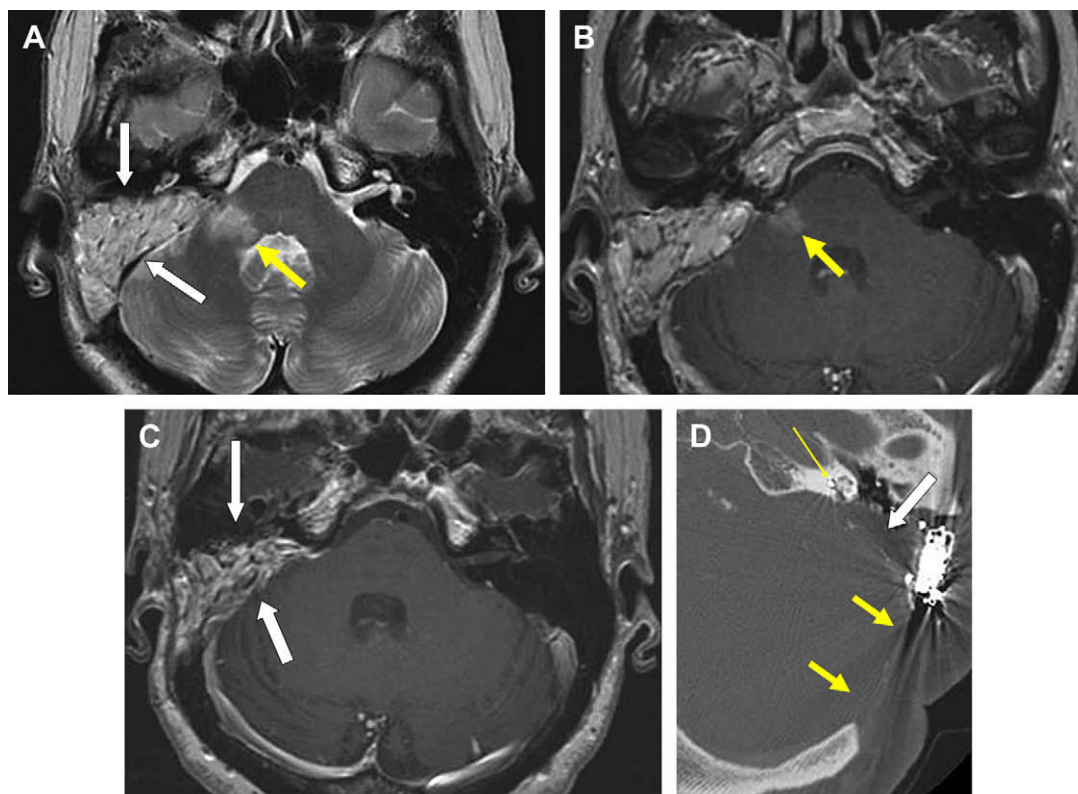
(A) Axial T2-weighted image following translabyrinthine resection of AS. Note the mixed fat and soft tissue graft (*white arrows*) filling the surgical defect, triangular in configuration, apex toward the IAC. There is increased T2 signal in the right cerebellar peduncle from ischemia (*yellow arrow*). (B) Axial T1-weighted image at the same level following contrast administration demonstrates enhancement in the right cerebellar peduncle (*arrow*). Findings were consistent with a small infarct postoperatively. (C) Axial postcontrast T1-weighted image in same patient 6 months later shows a diminishing volume of graft material in the surgical defect (*arrows*). (D) Axial CT in a different patient following combined retrosigmoid (*thick yellow arrows*) and translabyrinthine surgery (*white arrow*) with subsequent cochlear implantation (*thin yellow arrow*). Note the wide exposure of the cerebellopontine angle that can be achieved extending anteriorly toward the clivus.
